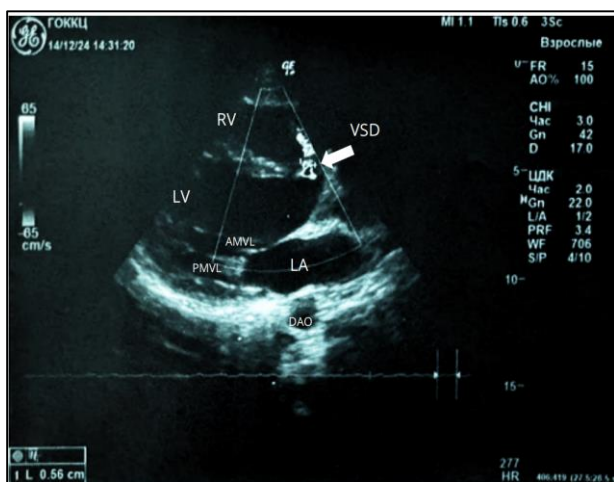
Echocardiography reveals ventricular septal defect (VSD). LA-left atrium, LV-left ventricle, AMVL-anterior mitral valve leaflet, PMVL-posterior mitral valve leaflet, RV-right ventricle, DAO-descending aorta.
